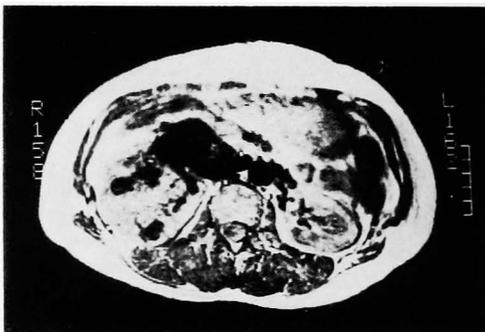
A proton density image of Fig. 9. The mass, suspected to be lymph node metastasis in the CT image, shows no signal in the image, and would be diagnosed as aggregate blood vessels at the renal hilum (eg. an enlarged and / or damaged vena cava due to tumor thrombus).
